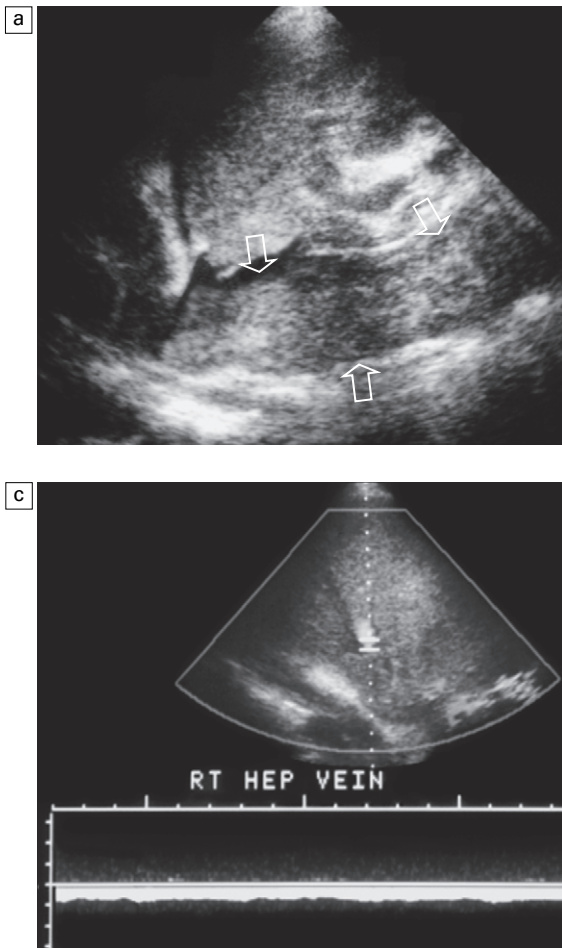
(a) Longitudinal view of the inferior vena cava in a patient with renal cell carcinoma. A large plug of tumour thrombus is seen extending in the inferior vena cava up to the level of the heart (arrows). (b) Transverse view of the liver. The inferior vena cava tumor thrombus (TT) obstructs the hepatic vein ostia. Note the distention of the hepatic vein (arrows). (c) Spectral Doppler tracing shows flattening of the hepatic vein flow profile and complete absence of periodicity. The triphasic waveform is not present, since cardiac retro pulsation cannot get past the tumour thrombus.
